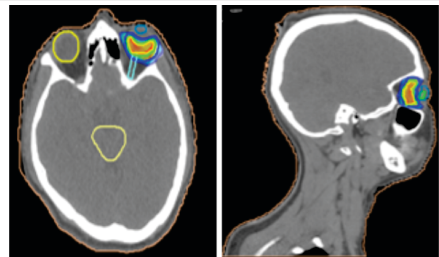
The axial and sagittal CT slices showing the conformal dose distribution using IMRT technique.
